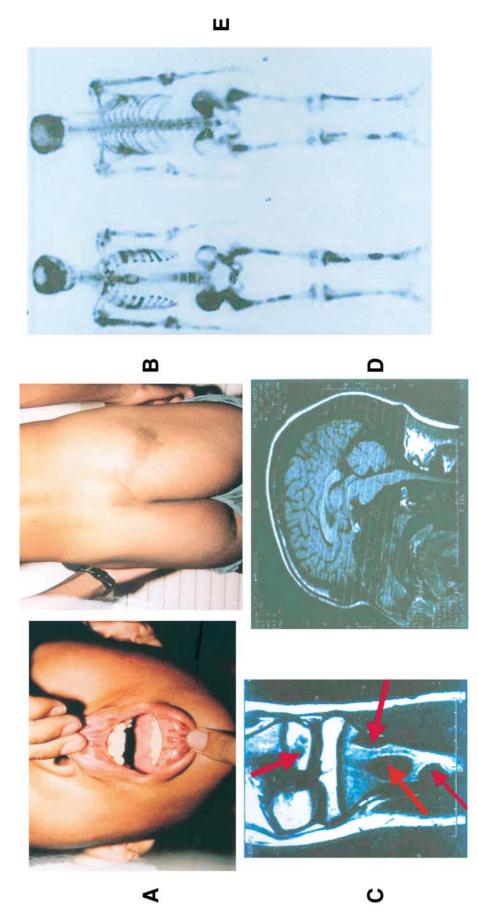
Skin and bone lesions in patient with MAS. (A,B) Multiple café-au-lait lesions with irregular borders over mucosa of labium maxillae and labium inferius oris, and over skin of right buttock; (C) polyostotic fibrous dysplasia involving left tibia; (D) MRI of sella showing normal size of pituitary, and bony frontotemporal overgrowth involving ethmoidal and sphenoidal bones; (E) 99TC-MDP scanning of bone revealing high radioactive uptake on multiple areas of skeleton.
